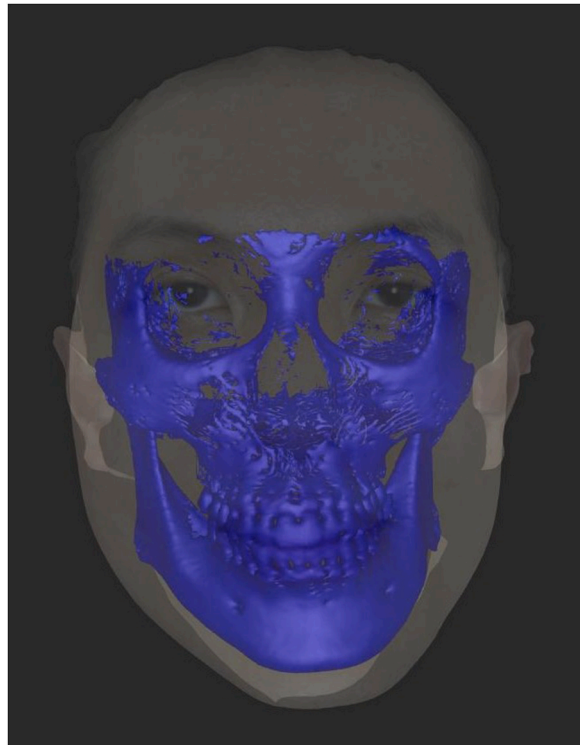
The CBCT and 3D facial surface images were automatically registered by the surface-based registration algorithm.
